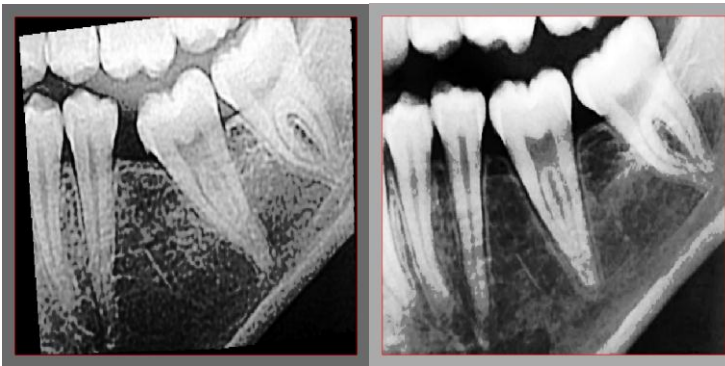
Radiographic image prior to and after orthodontic treatment (histogram equalized)
